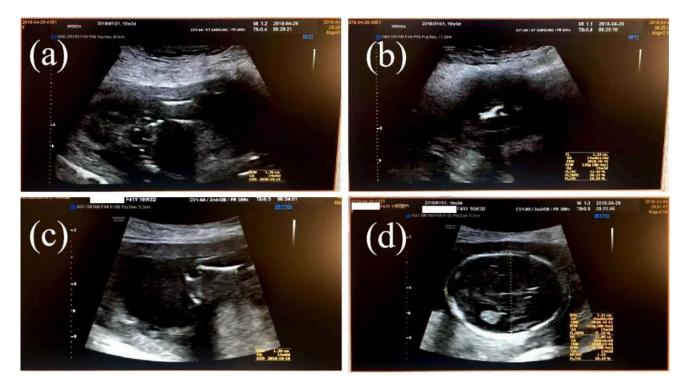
Ultrasound Atlas figures. (a) fetal humerus (14 w). (b) femur length (14 w). (c) fetal humerus (15 w). (d) biparietal diameter (14 w).
